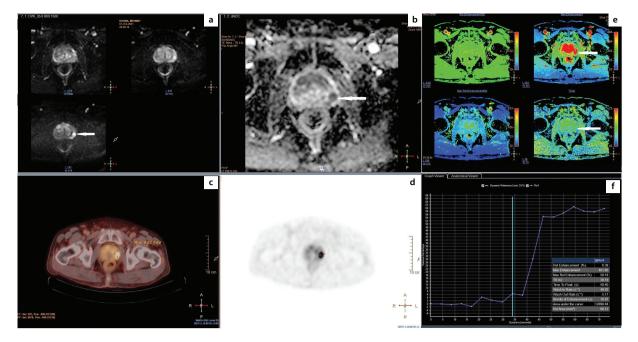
Peripheral zone with a PI-RADS 5 lesion, Gleason score 3 + 3, PSA: 6.84 µg/L, PSA-D: 0.21 ng/mL² (a) DWI (b = 0,600,1500 s/mm²) shows a marked hyperintense signal (arrow) above the background. (b) Apparent diffusion coefficient map reveals decreased signal intensity (arrow) in the lesion. (c, d) ⁽⁶⁸⁾Ga-PSMA-11 PET/CT images show avid uptake of radiotracer, with SUV_{max} of 9.82. (e, f) DCE-MRI time-intensity curve demonstrates a decline after initial up-slope enhancement. TTP: 59.4 s⁻¹; wash in rate; 49.03 s⁻¹, wash out rate; 5.17 s⁻¹. PI-RADS, Prostate Imaging–Reporting and Data System; PSA, prostate-specific antigen; DWI, diffusion-weighted imaging; PSMA, prostate-specific membrane antigen; PET, positron emission tomography; CT, computed tomography; SUV_{max}, maximum standardized uptake value; DCE, dynamic contrast-enhanced; MRI, magnetic resonance imaging.
